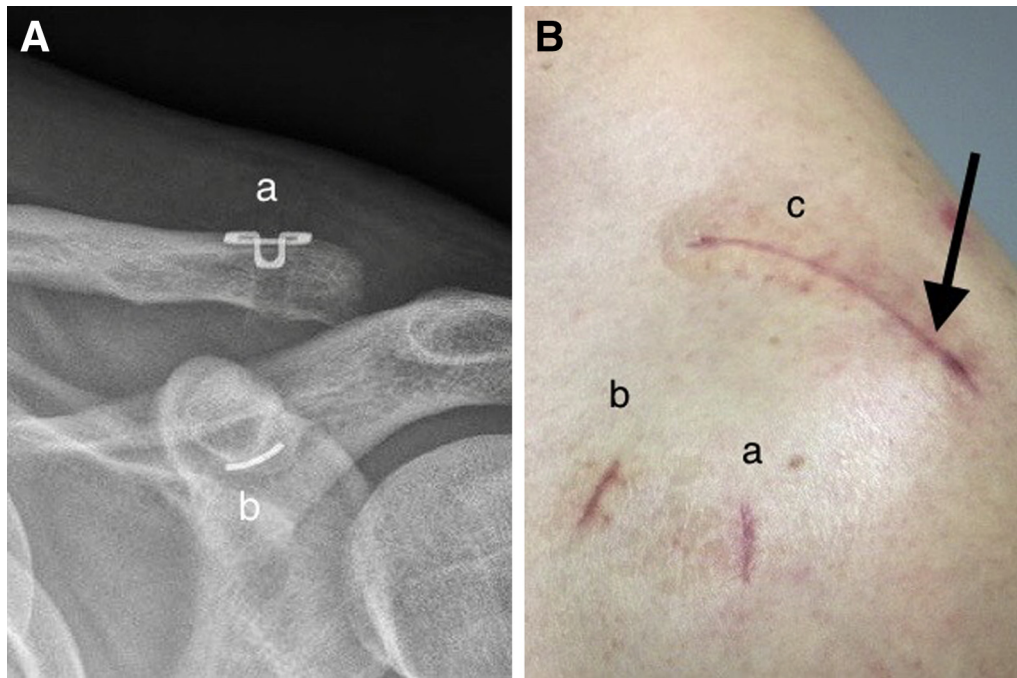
(A) The postoperative radiograph of a reduced clavicle. The superior part of the Clavicular Clip (16 mm) lies flush on the clavicular surface (a). The Subcoracoid Clip is in its position underneath the coracoid process (b). Left shoulder. (B) The skin wounds after 2 weeks from surgery. The lateral portal (a), anterolateral portal (b), and clavicular skin wound (c). Note that the clavicular opening is extended laterally to address also the acromioclavicular joint capsule (arrow). The initial dorsal portal is not visible in this projection. Left shoulder, anterolateral view.
